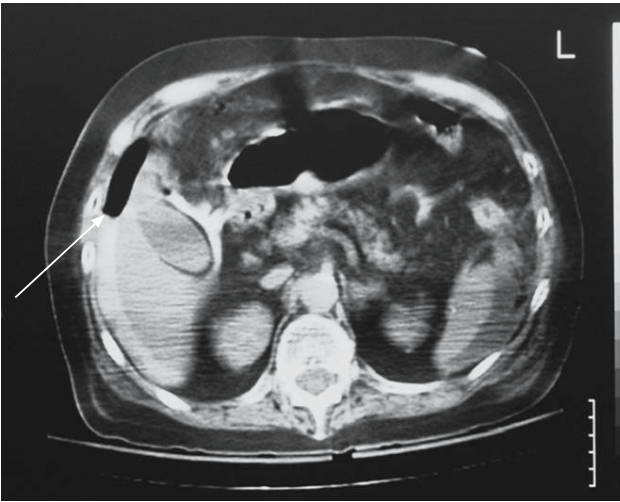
CT in a patient with perforated duodenal ulcer: free gas between the liver and anterior abdominal wall (*arrow*). Gas is also seen around the gallbladder and leakage of orally administered contrast is seen around the liver
